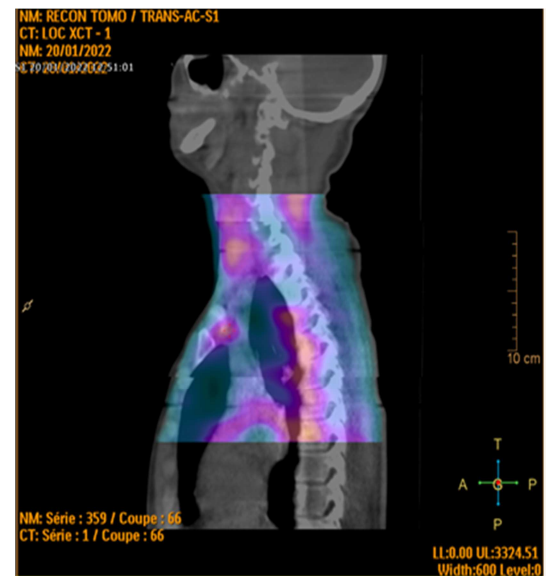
SPECT/CT acquisition (retro sternal hyperfixation).
